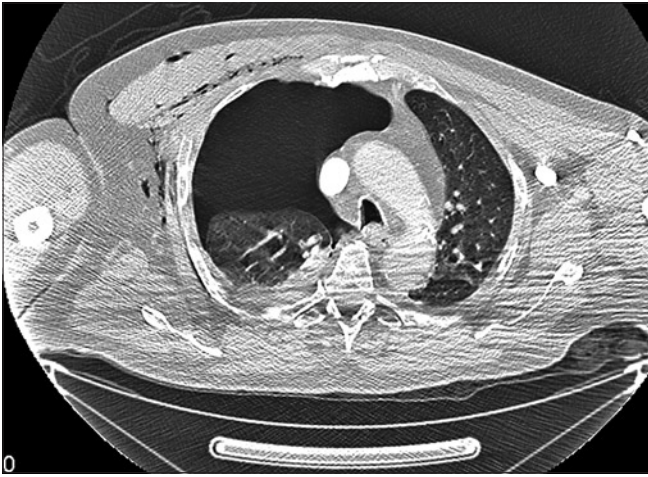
Tension pneumothorax – CT scan
